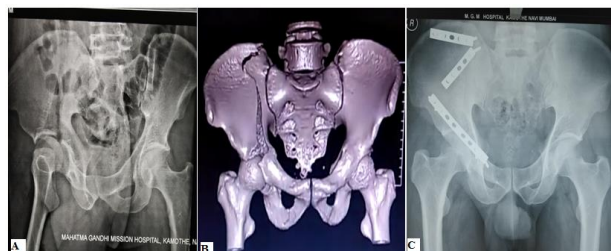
Preoperative PBH X-ray (A) and 3D CT scan image (B) shows fracture of acetabulum and postoperative PBH X-ray (C) shows fixation of fractures by plates.
